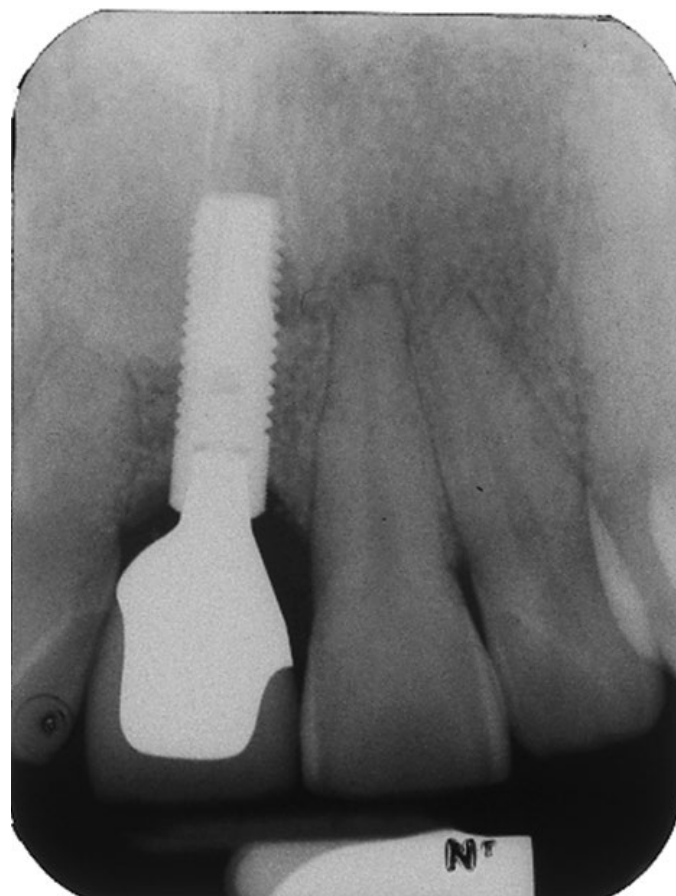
(D) Postcementation radiograph confirms complete cement removal in difficult to reach interproximal areas.
